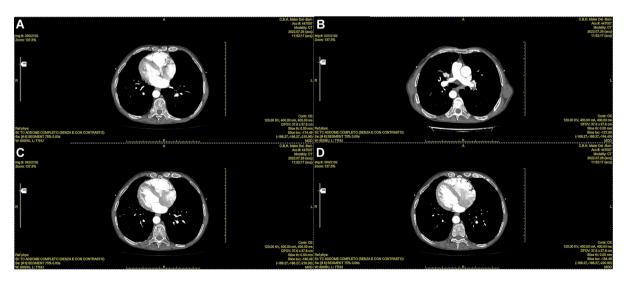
Computed tomography (CT) scans of the thorax showing the situs inversus. Specifically, the CT scans outlined the inversion of the sites of heart and great vessels
